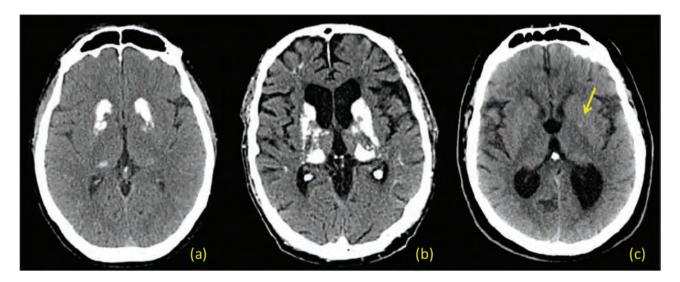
BGC on head CT scans. (A) Male, 53 years old, with familial hypoparathyroidism diagnosed at 7 years of age. (B) Male, 69 years old, with postthyroidectomy hypoparathyroidism since age 26. (C) 68-year-old male with hypertension, diabetes, and dyslipidemia with benign mineralization of the basal ganglia bilaterally, greater on the left (arrow).
